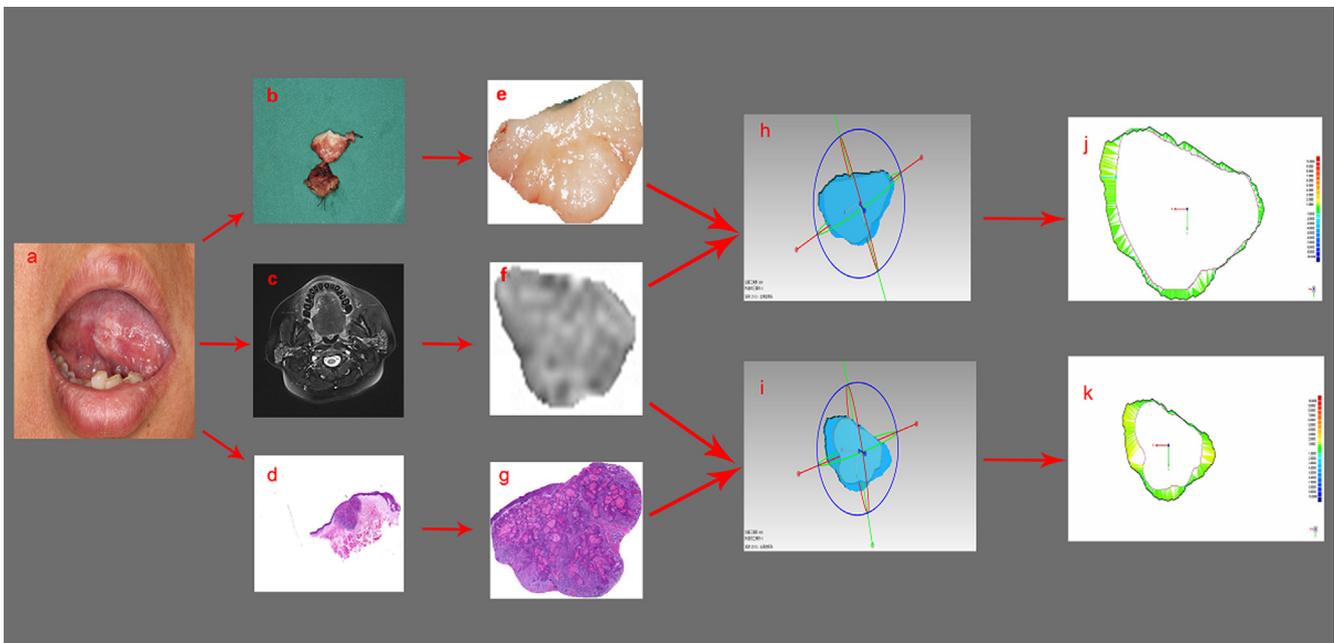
Two-dimensional analysis of tumor margins. a. Preoperative intraoral image of squamous cell carcinoma of the right lingual margin. b. Intraoperative tumor section image. c. Range of the tumor on magnetic resonance imaging based on the T2 sequence. d. Postoperative pathological scan. e–g. Separation and extraction of tumor images from intraoperative, MRI and pathological images. h–i: The Best Fit and artificial registration were used to fit the MRI data and intraoperative data; the pathological data and MRI data are in the same coordinates for two-dimensional comparison. j–k. Average difference of TD-DMP and TD-DMI.
